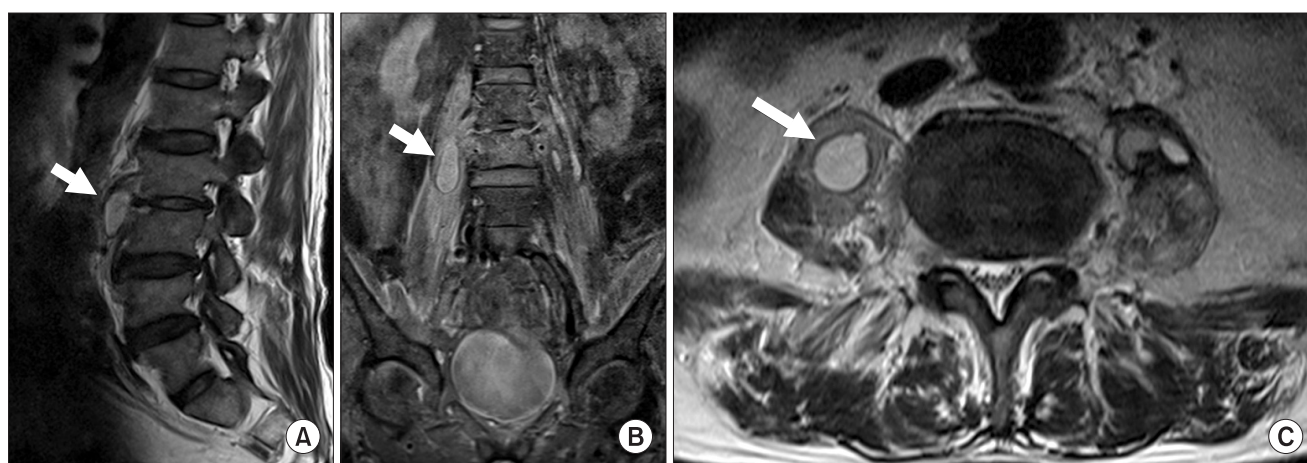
The lumbar spine MRI taken in December 2009. The psoas paravertebral abscess and infiltration with edema of the L3 vertebral body are seen. (A) The T2 sagittal image (B), the T2 Transverse image (C) and the T2 coronal image.
